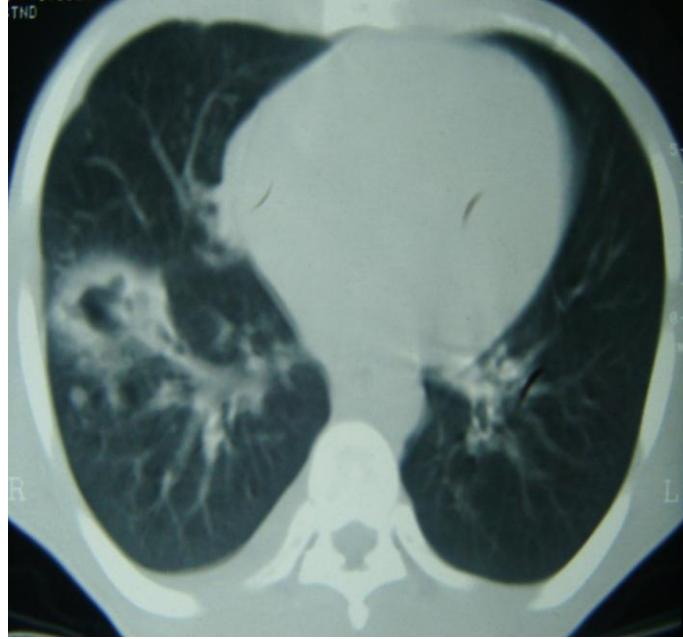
Thorax-CT of the right lung lower lobe segment anterobasal approximately 4x5 cm in size with smooth margins, heterogeneous density thick-walled cavitory lesion, and adjacent to the show nodular infiltrative appearance.
